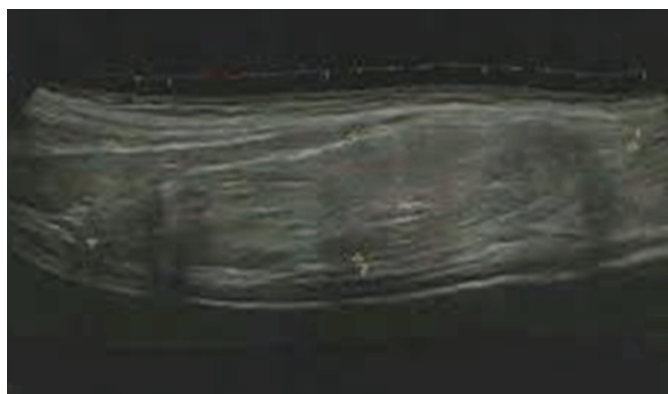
Avascular, homogeneous, hyper-echoic mass seen in the left lower extremity during Ultrasound examination. No evidence of calcification or tissue necrosis.
